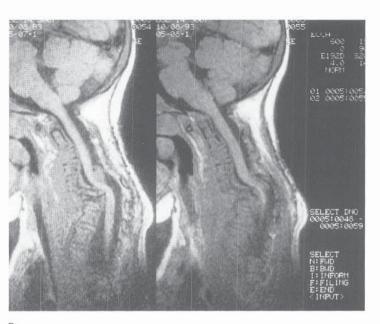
Neurofibromatosis. A. Lateral cervical radiograph of a 3-year-old child who had
